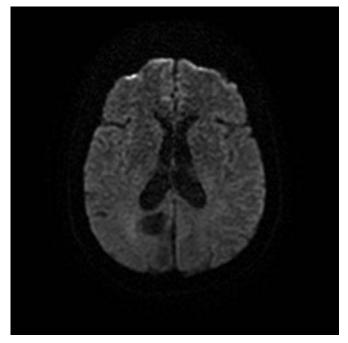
Diffusion sequence MRI, showing a hypointense right parietal tumor process.
